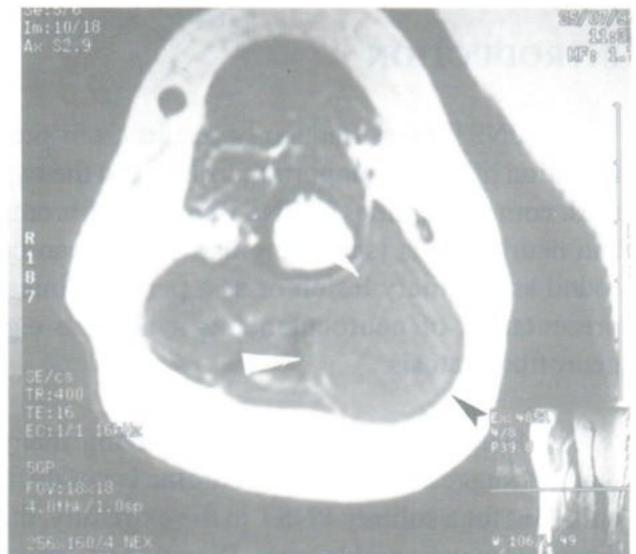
B : T1-weighted axial MR image reveals the mass to be slightly inhomogeneously isosignal to surrounding muscles (arrowheads).
